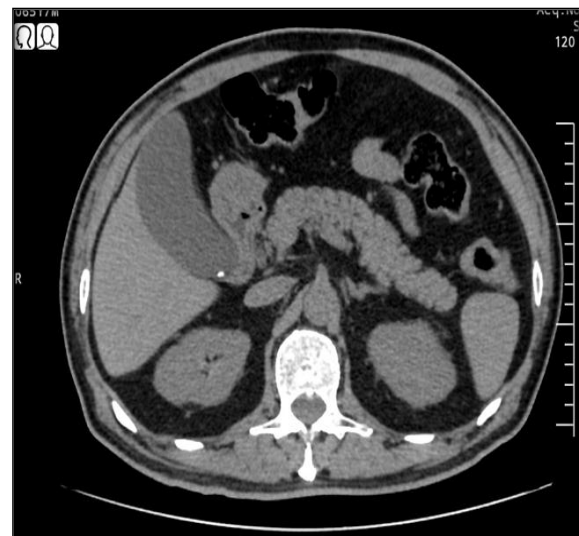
CT abdomen showing a distended GB with calculi.
